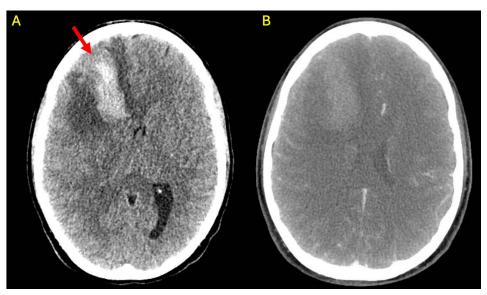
30-year-old female with bacterial endocarditis- CT.
